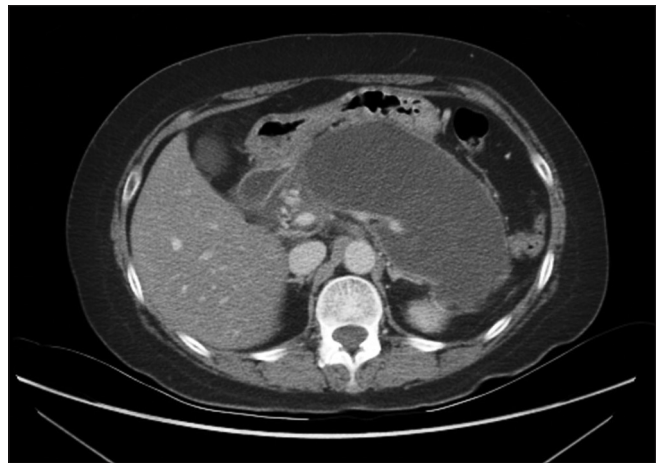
Walled off pancreatic necrosis. Two months after the first event of acute pancreatitis, a repeat computed tomography scan showed diffuse walled-off necrosis of the pancreas and pseudocyst formation
